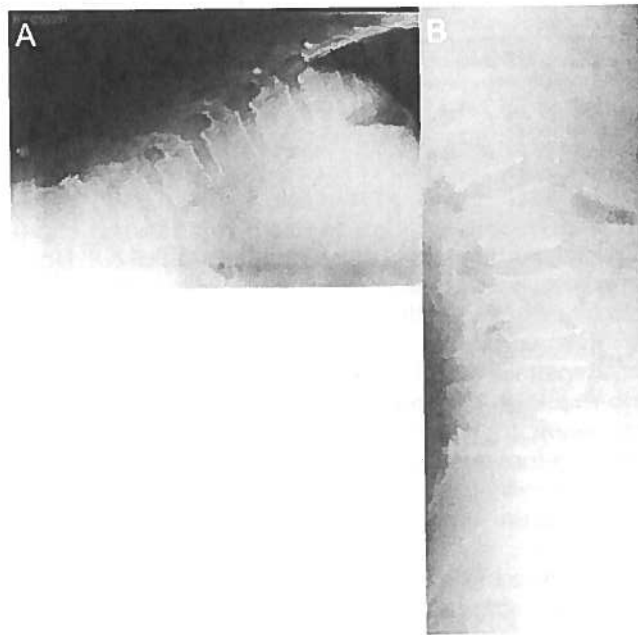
The post-operative dynamic X-rays film shows the good range of motion 2 years after the operation.
